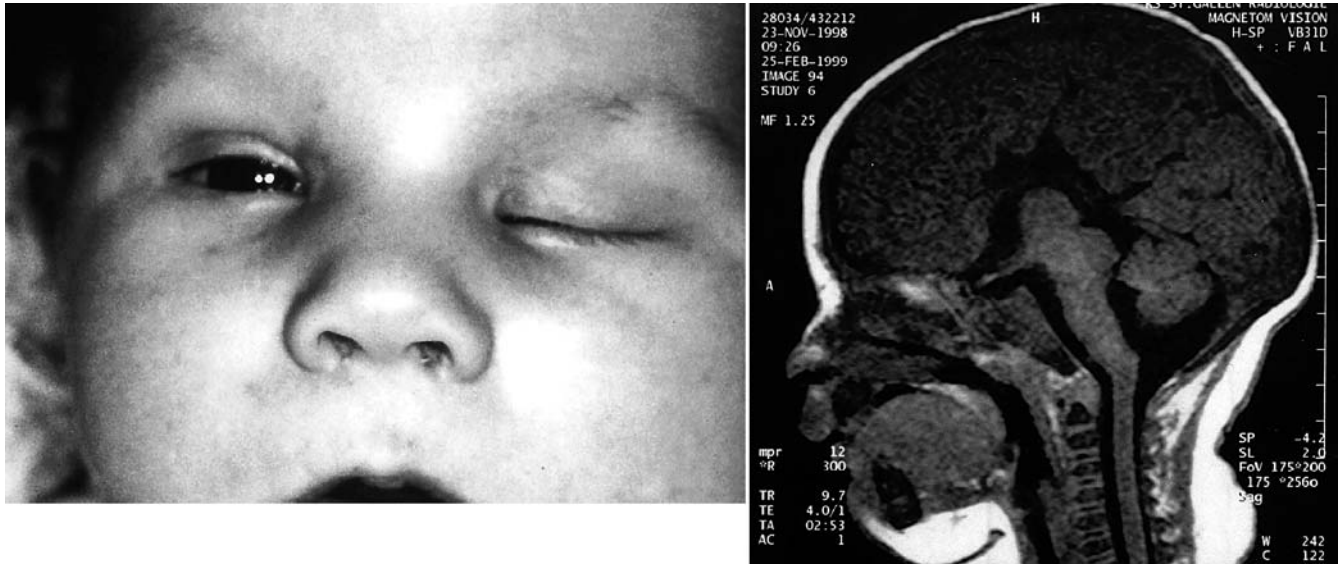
Patient 2 *Left*: The patient presents at birth with ptosis of the left eye and exotropia. *Right*: Cerebral MRI in the sagittal plane showing agenesis of the corpus callosum and vermian hypoplasia
